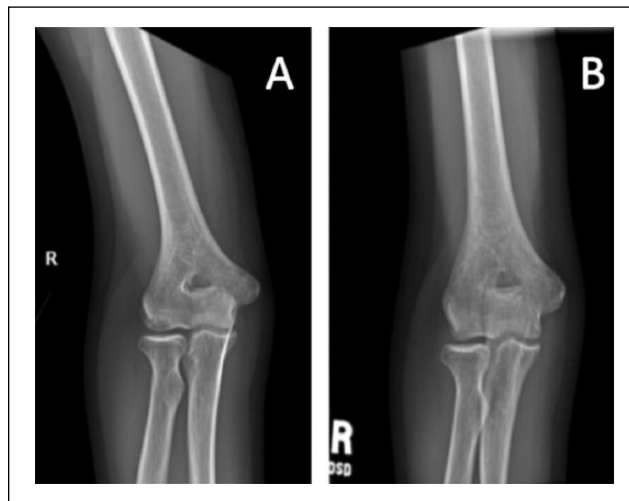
Anteroposterior plain films from a 13-year-old right-hand-dominant female gymnast/volleyball player who complained of 2 to 3 years of right elbow pain and mechanical symptoms during activity: (A) her preoperative films demonstrate a large Minami stage 2 capitellar defect; (B) her 3-month postoperative films demonstrate osseous integration of the graft and restoration of the articular surface.
